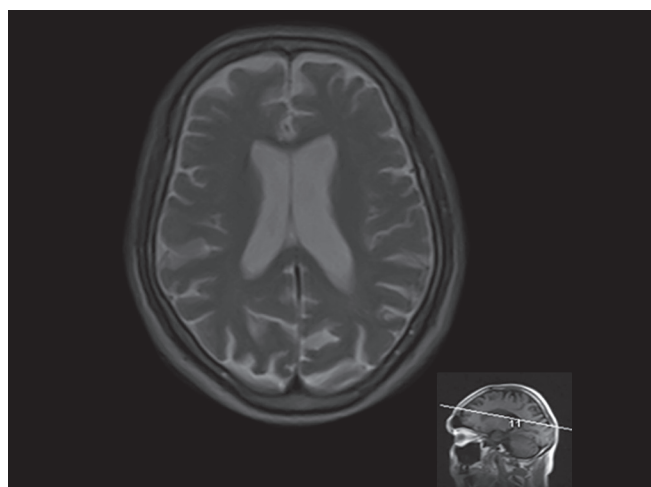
Magnetic resonance imaging brain showing age-related ischemic changes and cerebral atrophy
